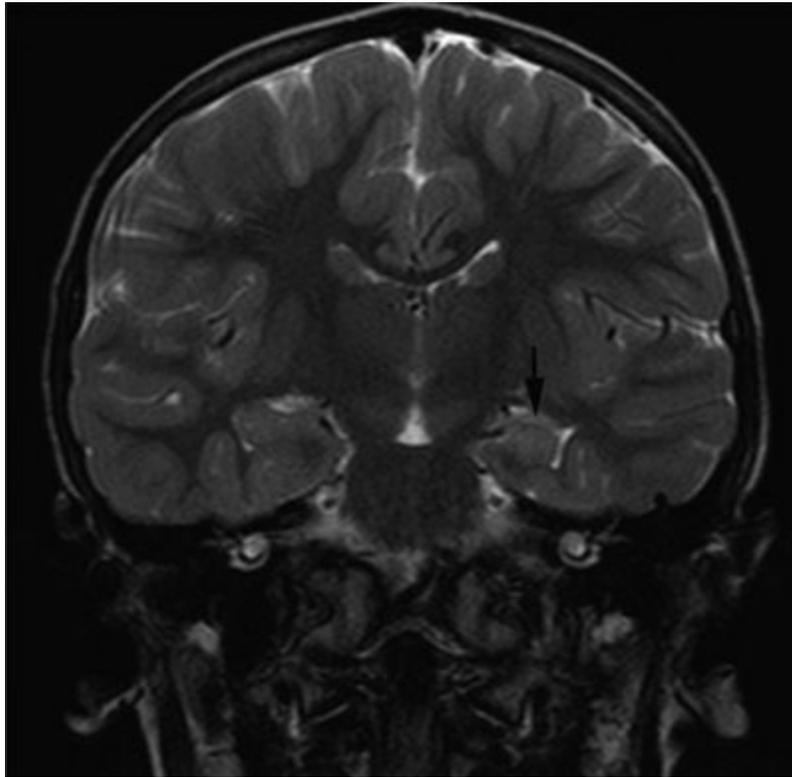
Mesial temporal sclerosis. Coronal T2-weighted image from MRI without gadolinium in a 7-year-old male with temporal lobe epilepsy shows increased signal intensity and decreased size of the left hippocampal formation (arrow).
